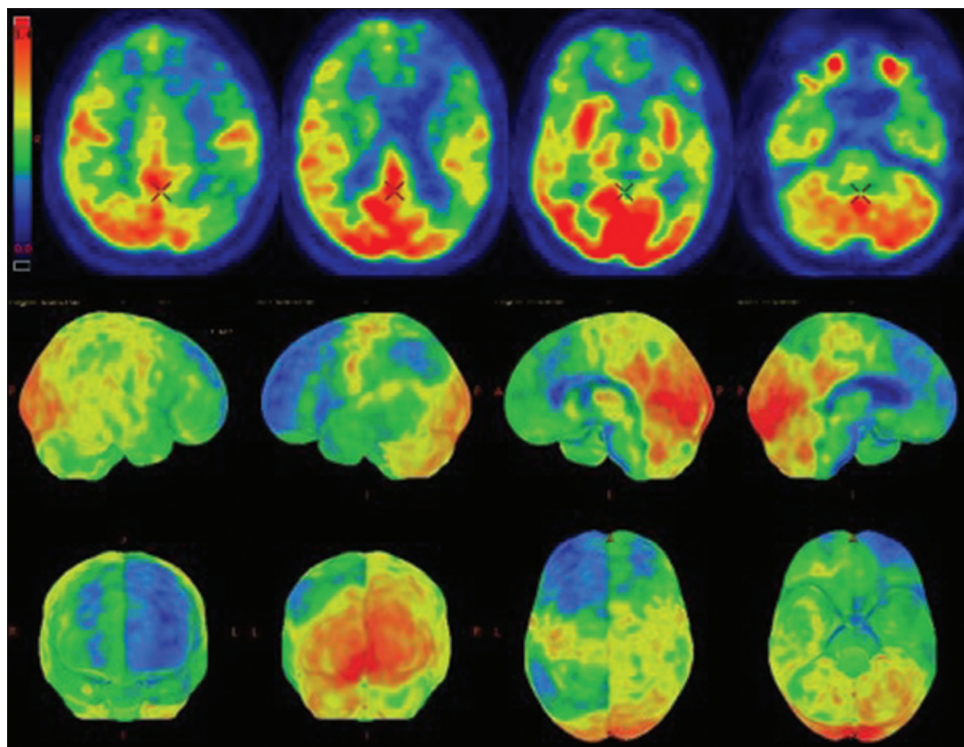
Transaxial $F^{18}FDG$ Brain PET images (top row) showing hypometabolism in the frontal (L>R), left parietal, and left temporal cortices and the left caudate. Relatively preserved tracer uptake is noted in both sensorimotor, posterior cingulate, and occipital regions, including the visual cortices, remaining subcortical gray matter, and both cerebellar hemispheres. Cortex id rendering (bottom two rows) reiterates the same with hypometabolism in the frontal (L>R), left parietal, and left temporal cortices
